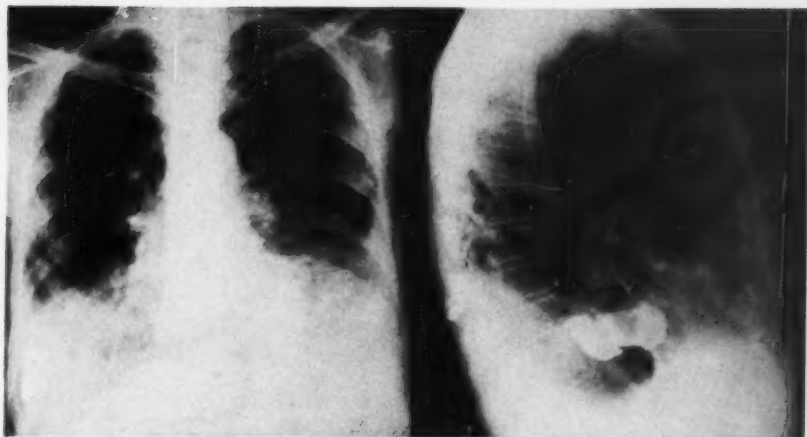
Postero-anterior and right lateral chest X-ray films showing bilateral pleural effusions. Residual lipiodol remains in the right pleural space from a previous investigation.
